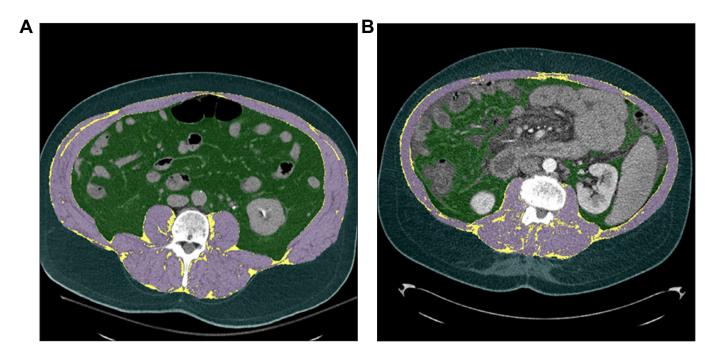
Sarcopenia. CT cross-sections at the L3 level for patients (A) without and (B) with sarcopenia.
